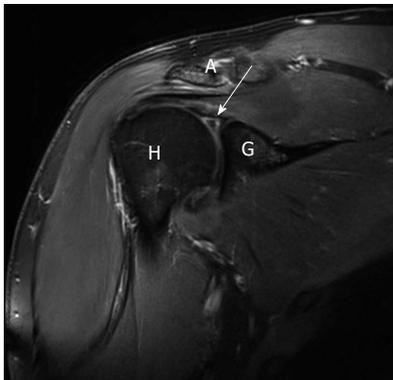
Superior labral anterior posterior III lesion: Findings in direct magnetic resonance arthrography. The coronal T1-weighted (cor t1 tse fs) fat-saturated image shows the separated triangle (arrow) of the bucket-handle without instability of the labro-bicipital complex. A: Acromion; H: Humeral head; G: Glenoid.
